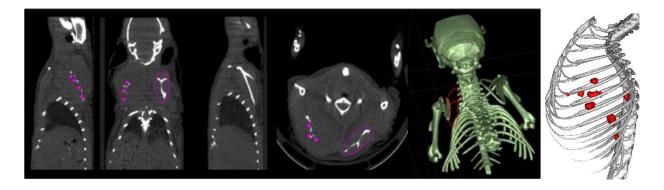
Computed tomography reconstructed images (2D and 3D)
